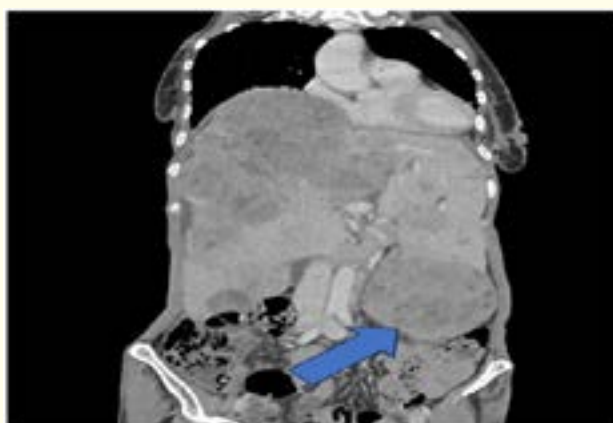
Coronal portal venous-phase contrast-enhanced CT image demonstrating hepatomegaly with multiple disseminated hepatic lesions. The largest lesion is exophytic, arising from segment III, projecting into the intraperitoneal cavity and (Blue arrow).
